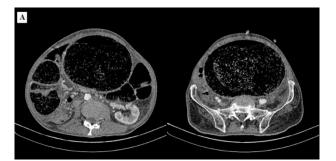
A huge fecaloma observed in the abdominal CT scan
